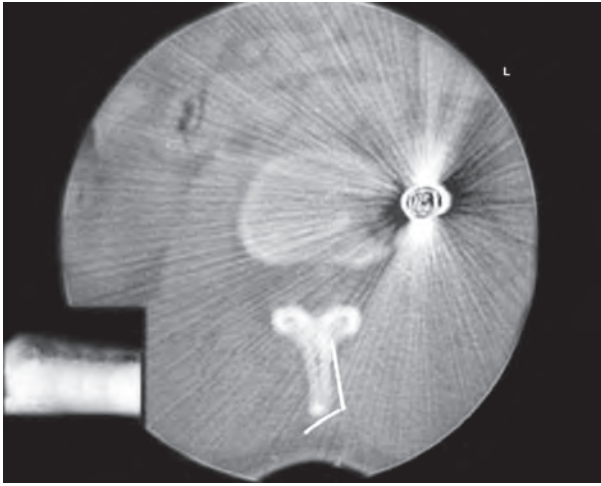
CT showing missile lodgement near the vertebral body
